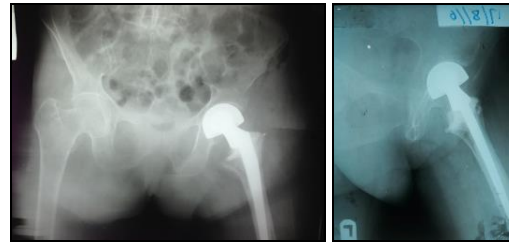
(c, d) postoperative radiograph for left hip
